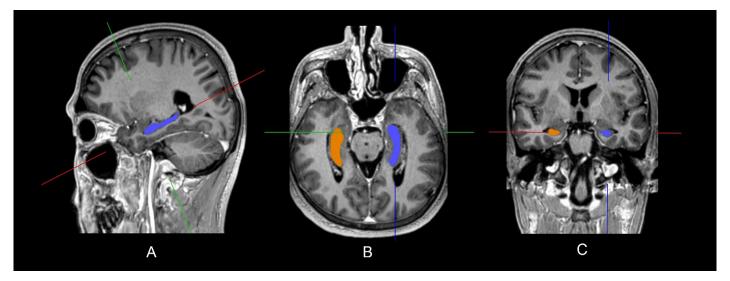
Multiplan demonstration of determined hippocampus borders in the long axis on the MR images.
